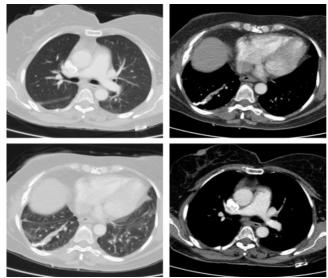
Changes in sequela on postoperative thoracic CT
